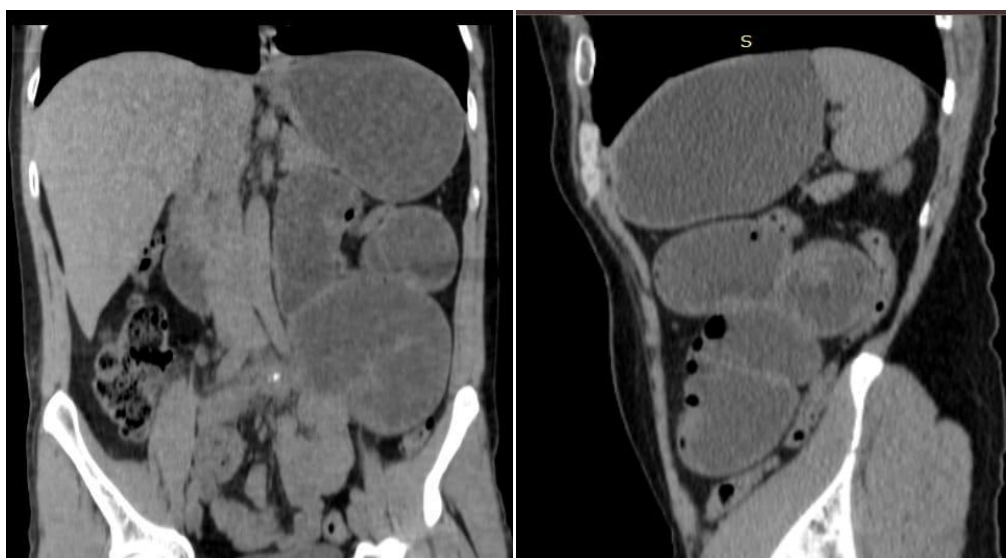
Coronal and sagittal views, respectively, of the same CT scan, shows the dilated small bowel loops (jejunum) and other collapsed bowel loops as in Fig. 1
